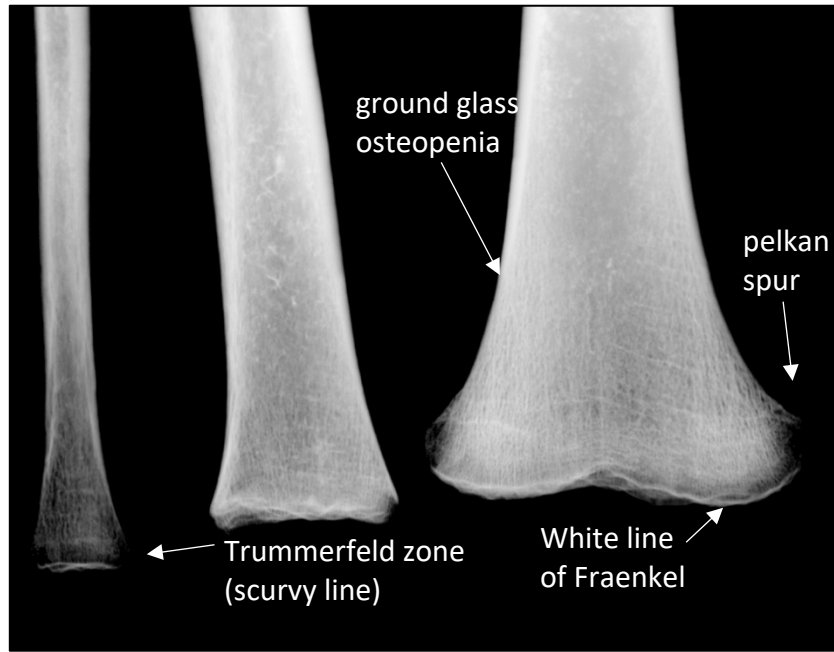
Radiographic features of scurvy. (Edo Period Japan). Image: author's own
